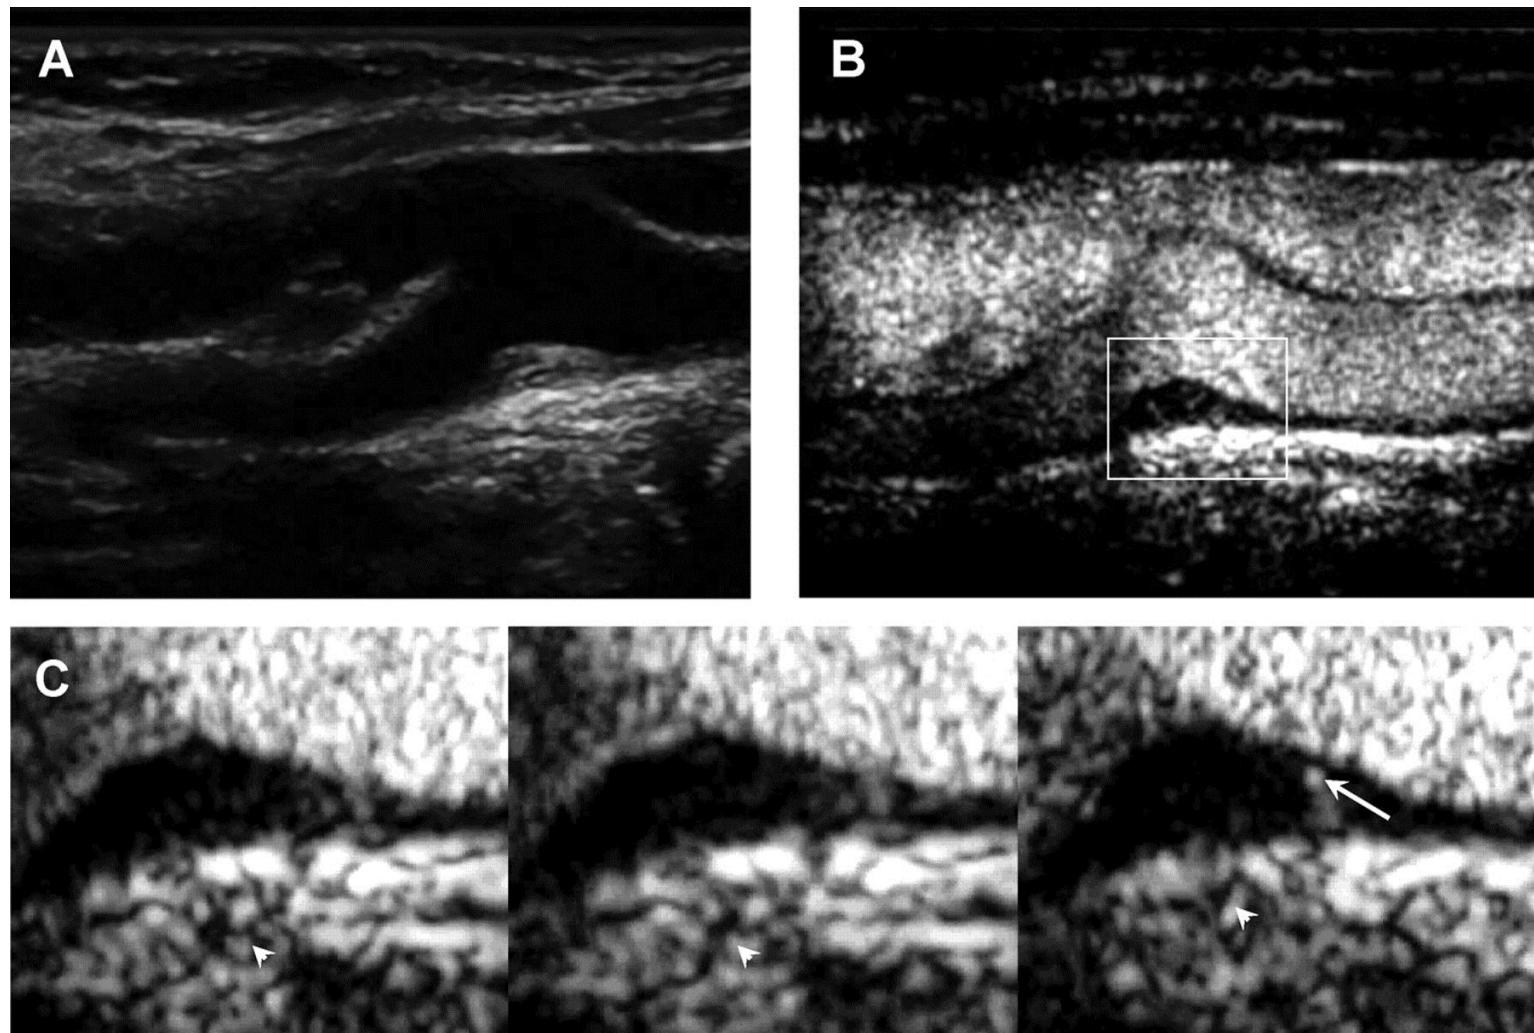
Carotid artery with vasa vasorum grade 2 on contrast-enhanced ultrasound.
